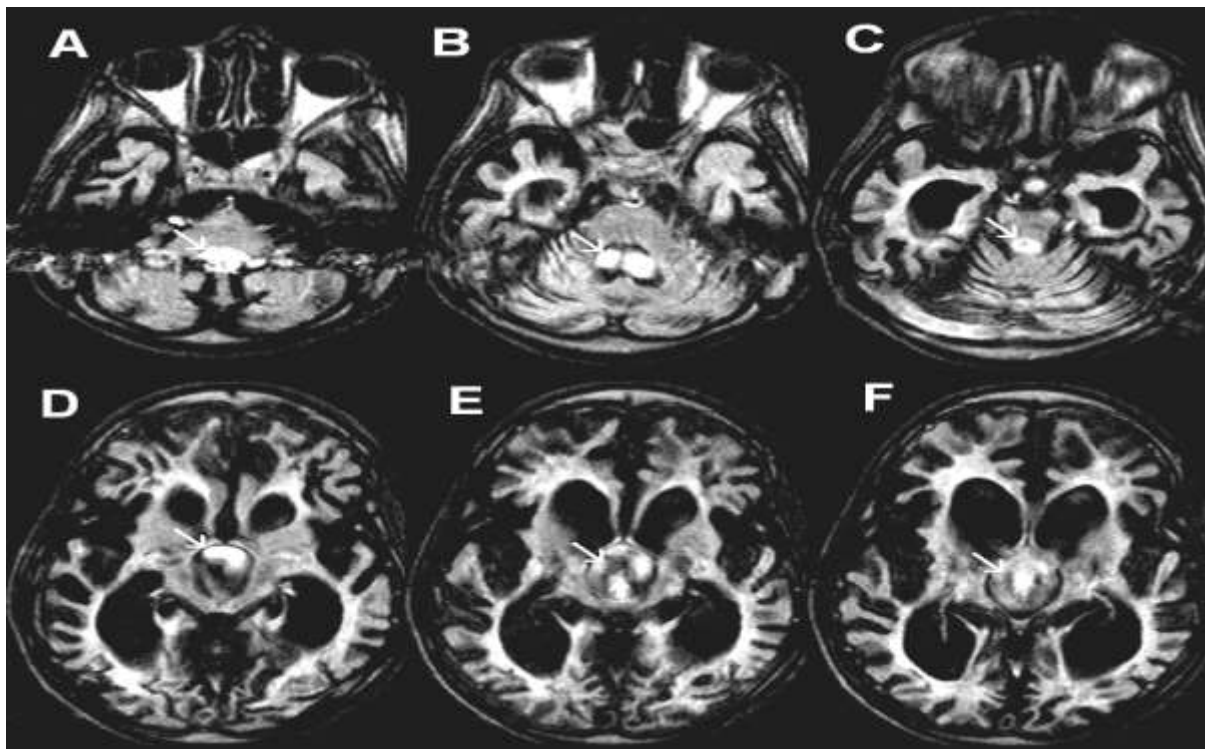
presents the FLAIR axial image of patient JM, demonstrating a huge atrophy with ventriculomegaly. A severe ventricular CSF pulsation artifact (arrows) is visualized in the fourth ventricle (A-B), aqueduct (C), and third ventricle (D-E).
